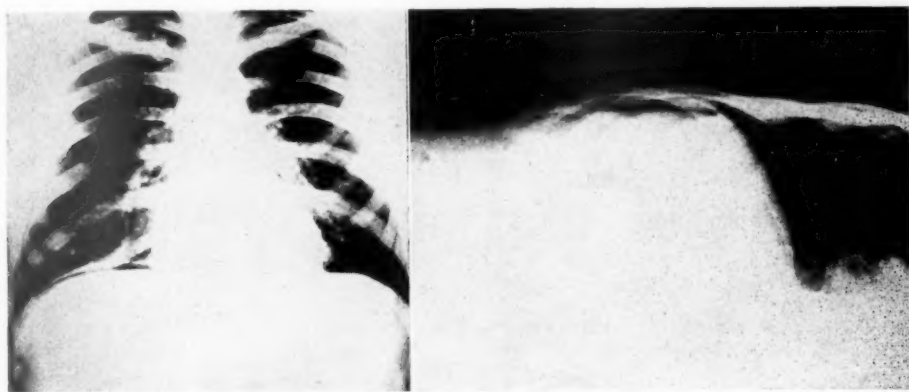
Admission roentgenograms of Case 15 in upright and left lateral decubitus positions showing free intraperitoneal air.
